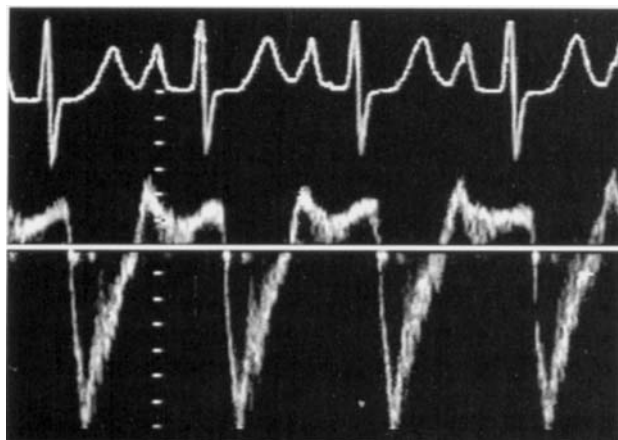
Holodiastolic flow reversal in the descending thoracic aorta due to severe aortic regurgitation. Spectral display of pulsed wave Doppler with sample volume located in mid-descending thoracic aorta. Antegrade flow is below the baseline, and retrograde flow reversal is above the baseline. Scale is 10 cm/s between each mark.
